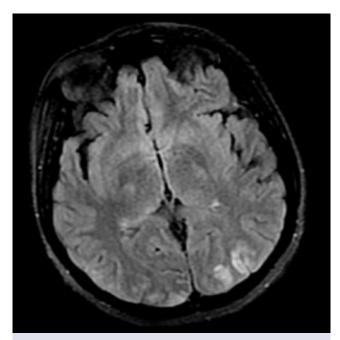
Axial FLAIR image showing focal hyperintensities affecting the cortical and subcortical areas of the bilateral occipital lobe, consistent with PRES. No diffusion restriction was observed (data not shown).
